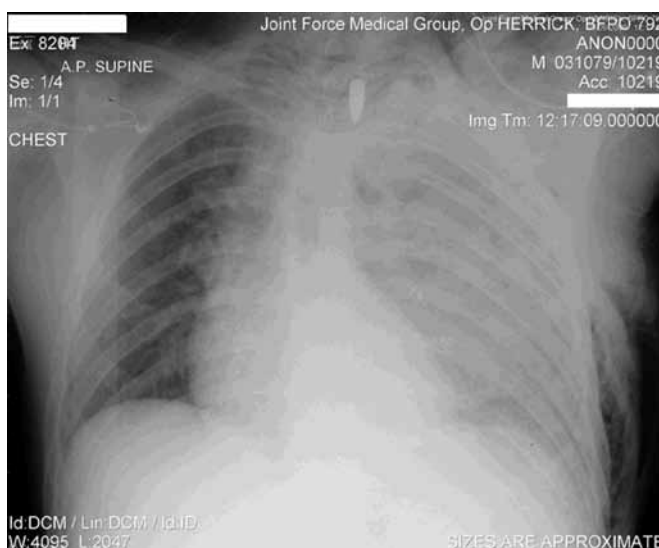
Chest radiograph showing injury to left chest and retained round.
